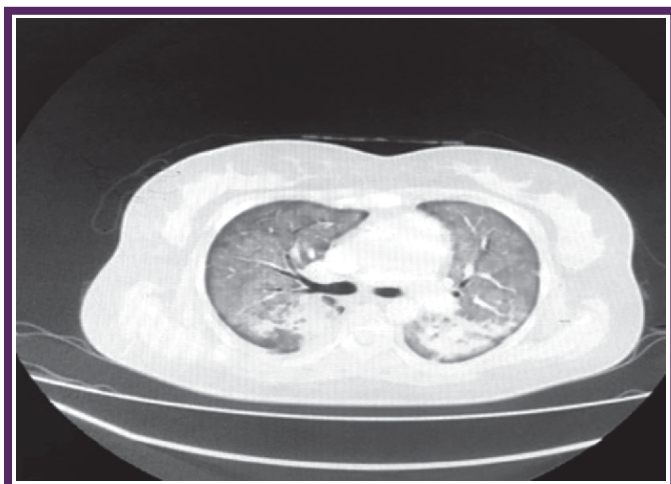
CT chest showing infiltrate in both lung field with alveolar hemorrhage in both lungs
